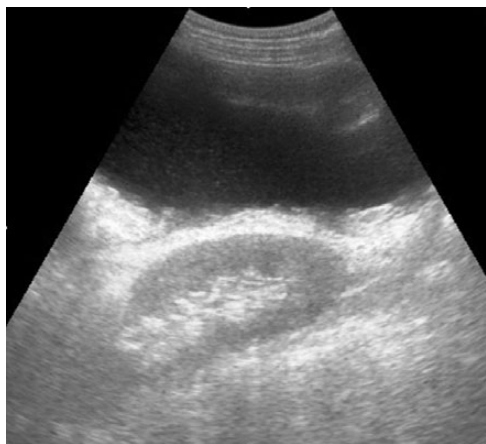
Abdominal sonography showing gross ascites.
